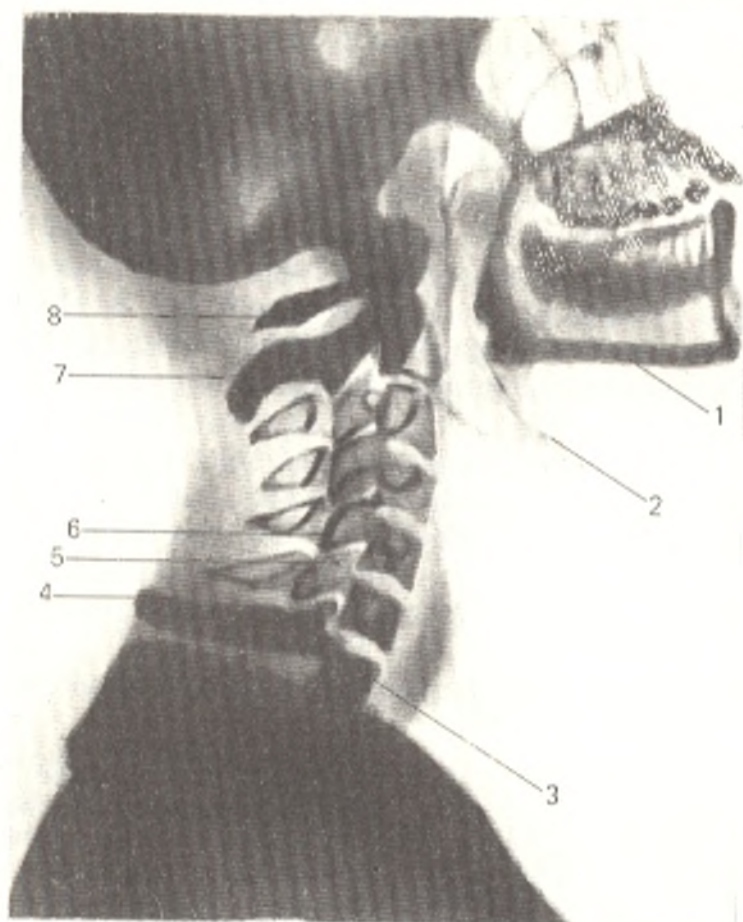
Radiograph of the cervical vertebral column (lateral view).
